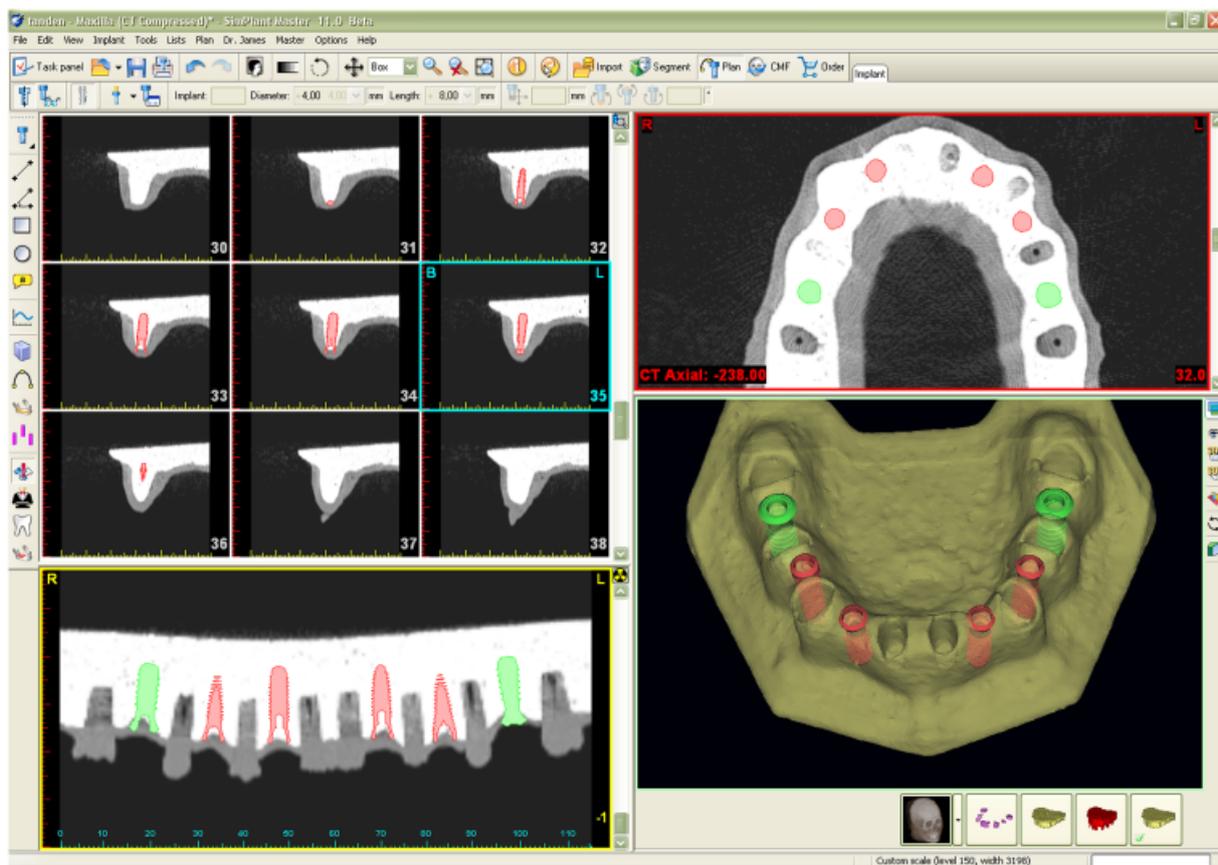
The treatment plan was done on the CT scan data of the model imported in SimPlant[®] PRO 9.2 (Materialise NV, Leuven, Belgium)
